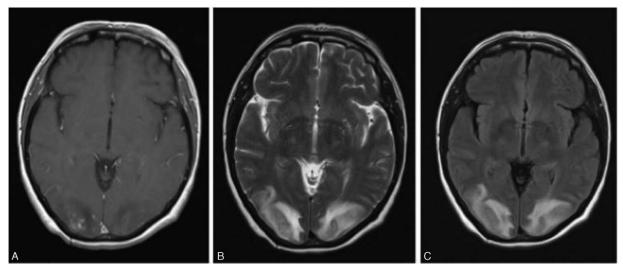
(A) T1-weighted MRI of patient MR reveals minimal abnormality. (B) T2-weighted MRI reveals bilateral symmetric hyper-intensities in the posterior occipital lobe consistent with vasogenic edema of PRES. (C) FLAIR sequence again reveals bilateral symmetric hyper-intensities of the posterior occipital lobe consistent with PRES. MRI = magnetic resonance imaging, PRES = Posterior reversible encephalopathy syndrome.
